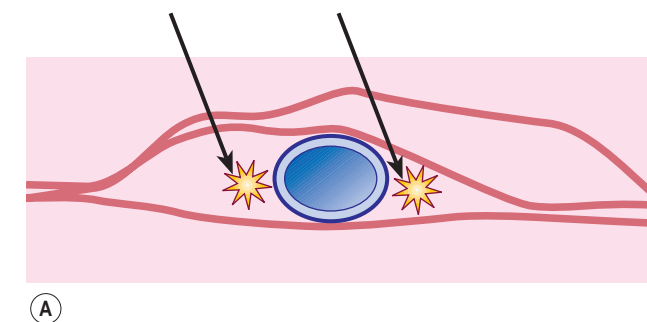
Points of injection for ultrasound-guided semitumescent local anesthesia.
